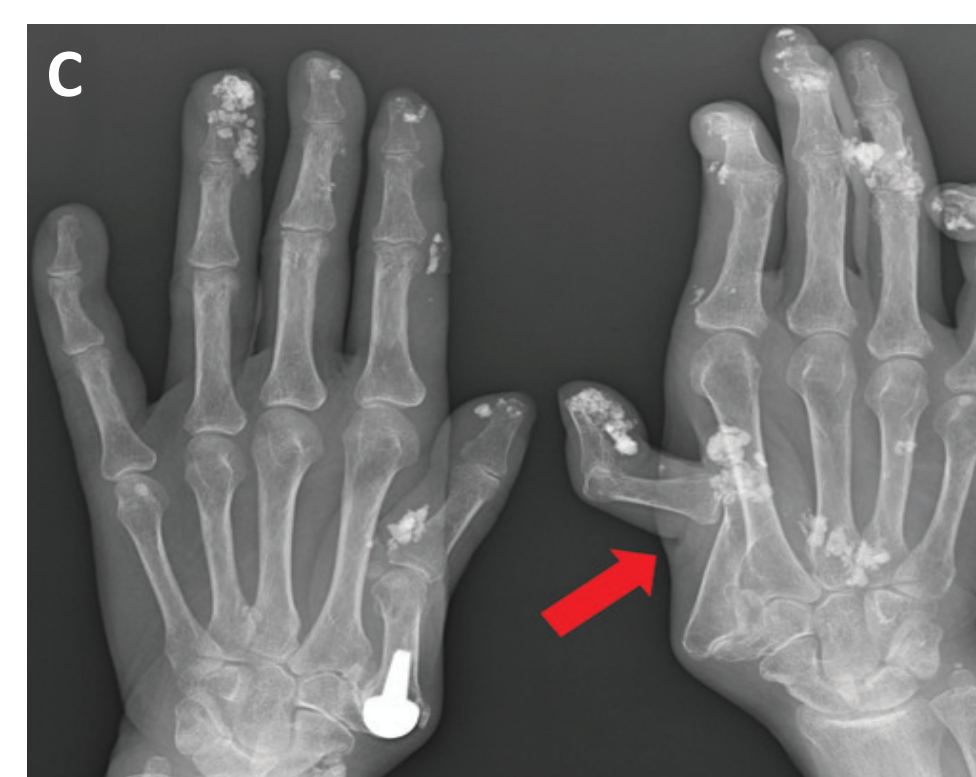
Calcinosis in SSc. Multiple areas of right hand calcinosis (A&B), which are easily seen on radiography (C). Arrows indicate right thumb calcinosis. Wrist calcinosis as seen on radiography (D) and CT (E). From Herrick and Gallas 2016.
